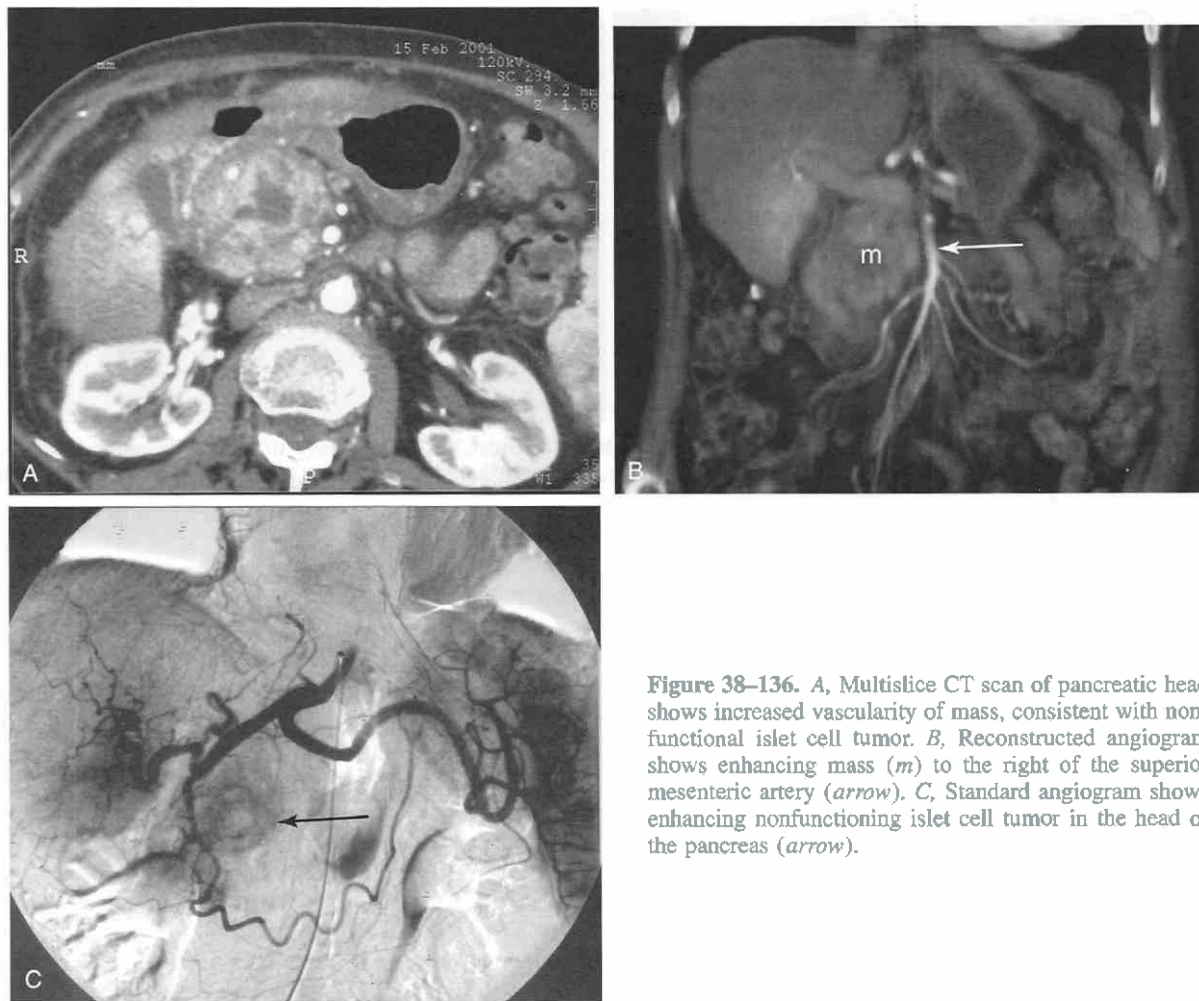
A, Multislice CT scan of pancreatic head shows increased vascularity of mass, consistent with non-functional islet cell tumor. B, Reconstructed angiogram shows enhancing mass (*m*) to the right of the superior mesenteric artery (*arrow*). C, Standard angiogram shows enhancing nonfunctioning islet cell tumor in the head of the pancreas (*arrow*).
